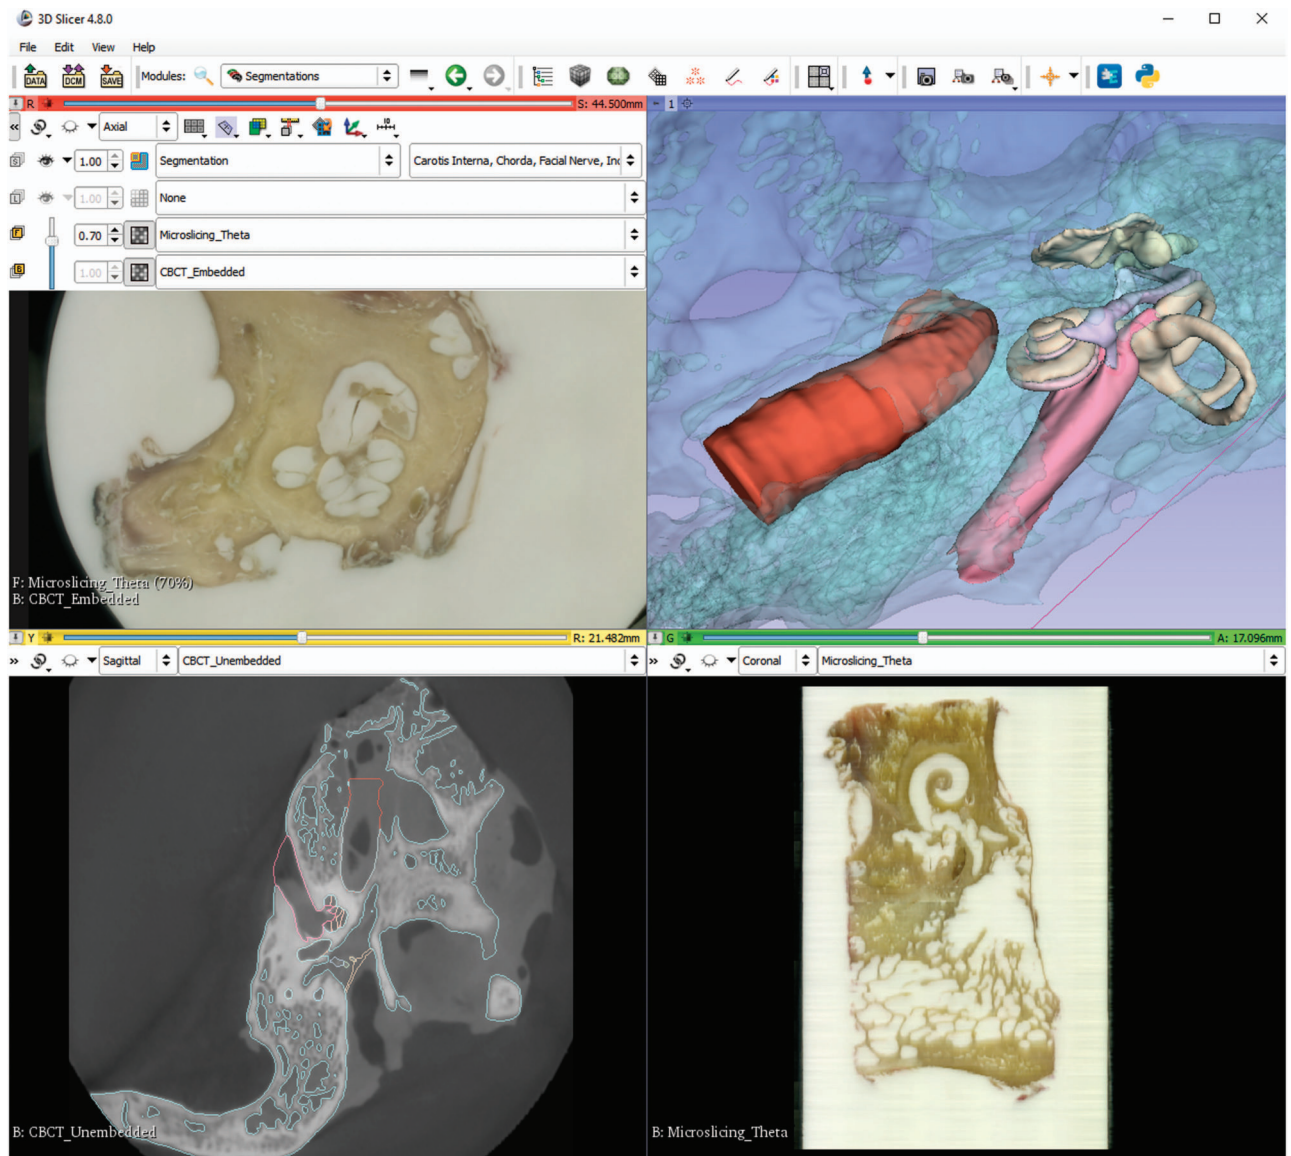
3D Slicer visualization of different imaging modalities of the Theta dataset. (a) Image fusion slice with 30% CBCT and 70% micro-slicing. (b) Three-dimensional reconstruction of anatomical segments from delineation. (c) CBCT slice with anatomy segmentation delineation overlay. (d) Reconstructed slice from micro-slicing.
